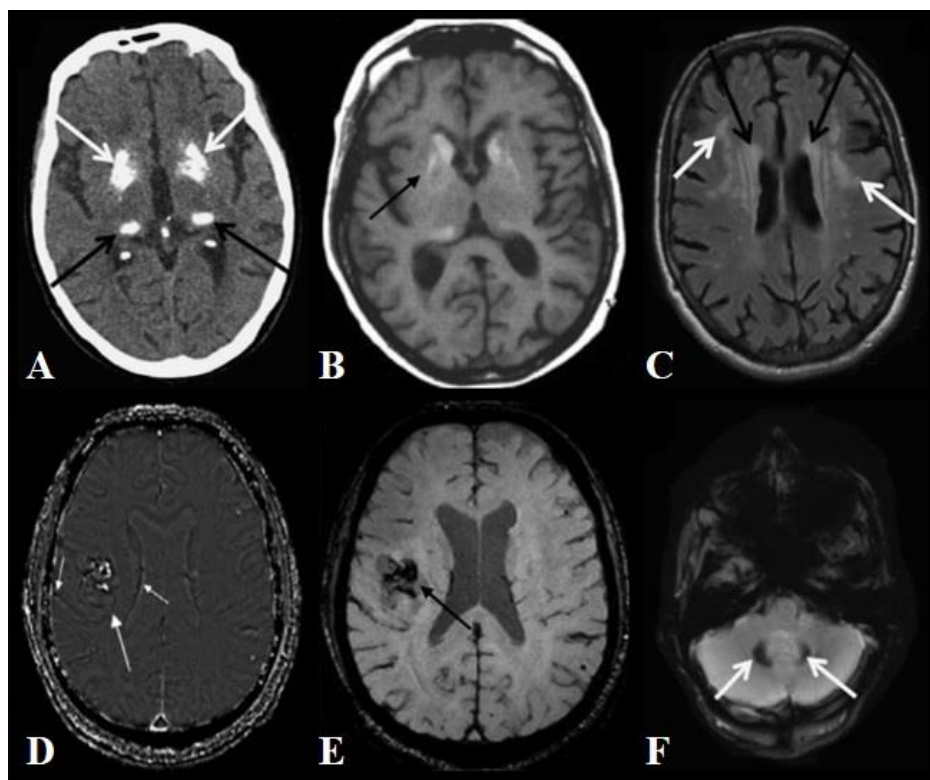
Plano horizontal do cérebro em diferentes técnicas de neuroimagem. (A-D) As setas indicam depósitos calcificados no cérebro com sinais hiperdensos ou hiperintensos (brilhantes). (A) Tomografia Computadorizada (Nicolas *et al.*, 2013), (B) RM na sequência T1 (Filloux, Marotte e Miossec, 2003), (C) RM na sequência FLAIR (Nicolas *et al.*, 2013), (D) RM na sequência SWI com filtro de fase (Wu *et al.*, 2009). (E-F) As setas mostram regiões escuras (hipointensas) indicando a presença de calcificações nessas áreas. (E) RM na sequência SWI com magnitude (Wu *et al.*, 2009), (F) RM na sequência T2 (Nicolas *et al.*, 2013).
